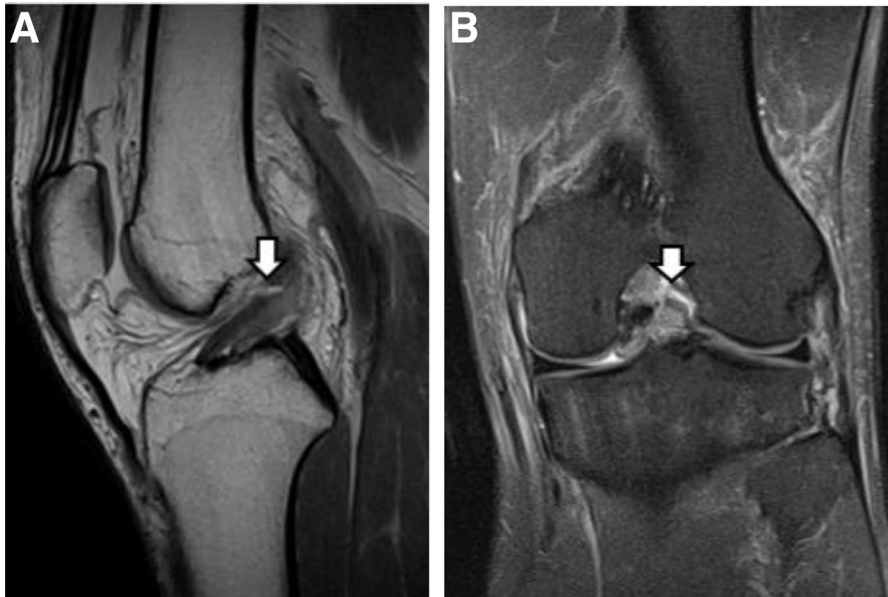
Sagittal (A) and coronal (B) magnetic resonance imaging of left knee showing Sherman type 1 tear patterns of the femoral avulsion (arrows).
